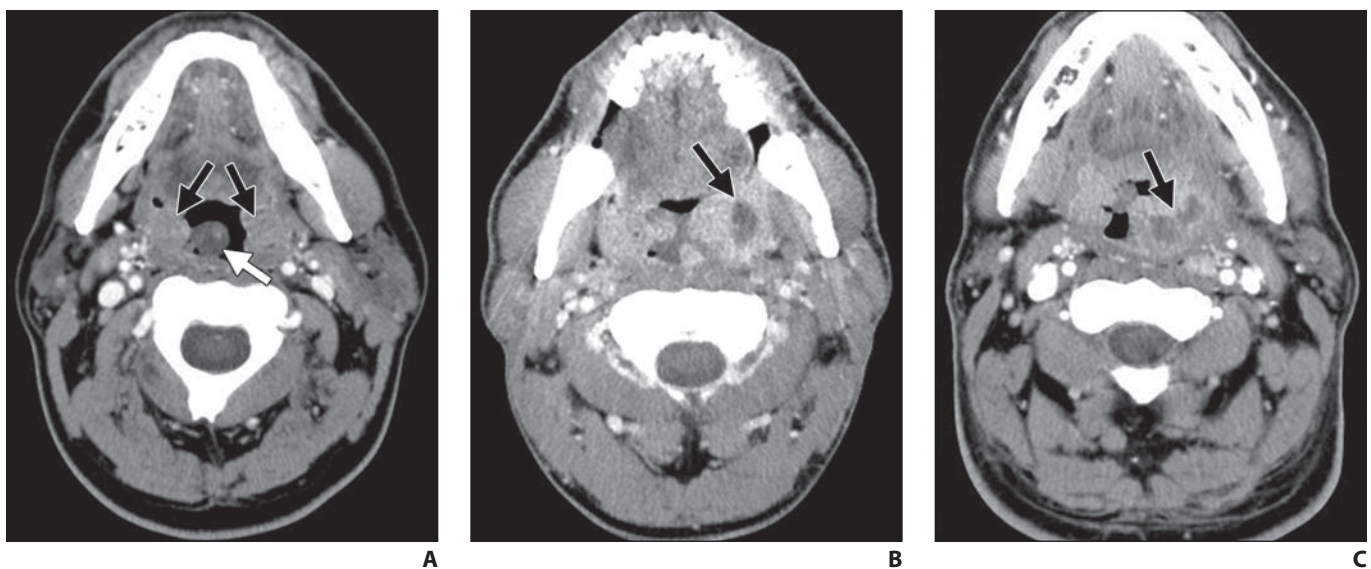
Axial contrast-enhanced CT images in three different patients show infections within pharyngeal mucosal space. (Reprinted from *Radiol Clin North Am* Vol. 53, Kubal WS, Face and neck infections: what the emergency radiologist needs to know, 827–846, Copyright 2015, with permission from Elsevier)
